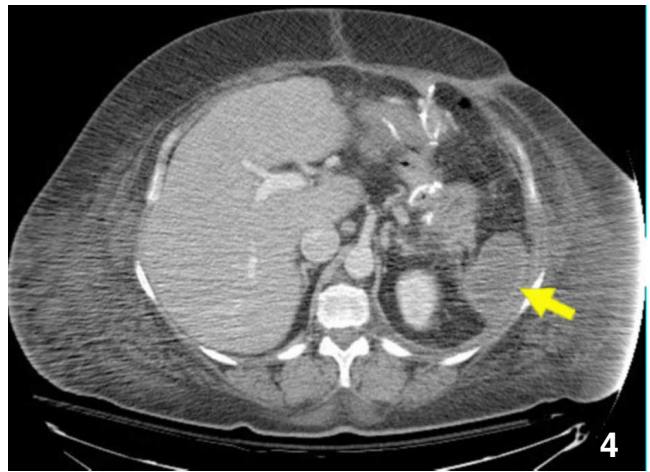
Abdominal CT scan obtained 5 days post-embolization shows artifact from metallic coils within the splenic artery and a nonenhancing spleen, compatible with splenic infarction (arrow).
